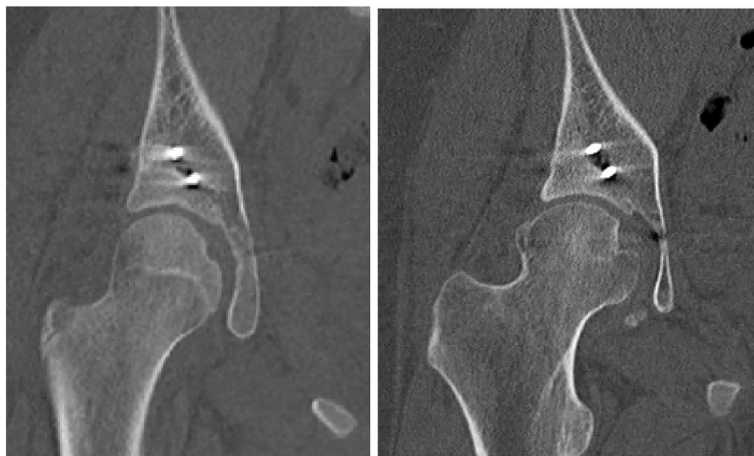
A and B. Representative slices of CT scans at the same depth taken 2 years apart demonstrate the interval development of CAM lesion of femoral head. A). Immediate postoperative CT scan. B). 14 months postoperatively the posterior wall fracture has healed with no degenerative changes seen. There has been interval development of a CAM lesion.
